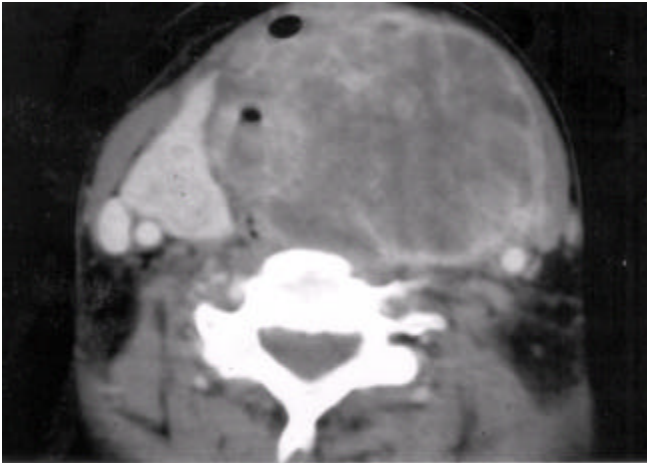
After one month from the admission, the second CT imaging of the neck showing a huge necrotic mass originating from left lobe of the thyroid
